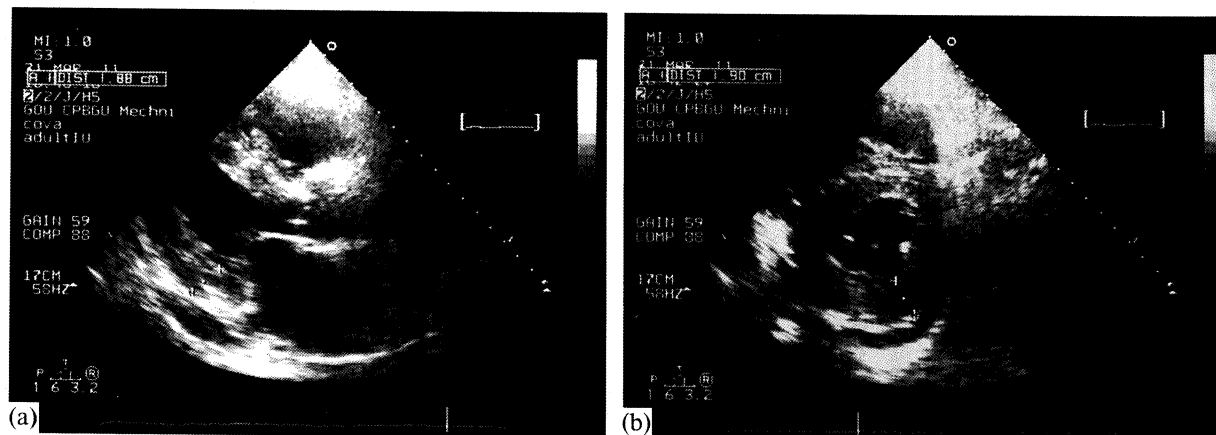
Echocardiographic image of the heart. Parasternal position, long axis (a), short axis (b). Increased myocardial echogenicity (the phenomenon of "brilliant myocardium").
